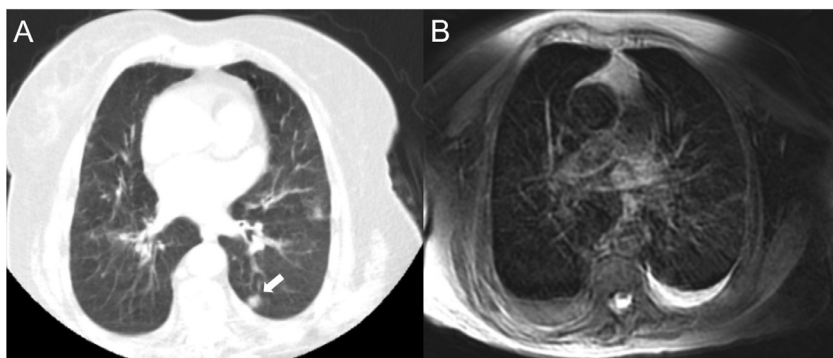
An 82-year-old female patient with heart failure and chronic obstructive pulmonary disease, presenting with a nodule in the superior segment of the left lung lower lobe displayed clearly on CT (a, arrow), but with poorer quality on MRI (b) due to intense artifacts.
